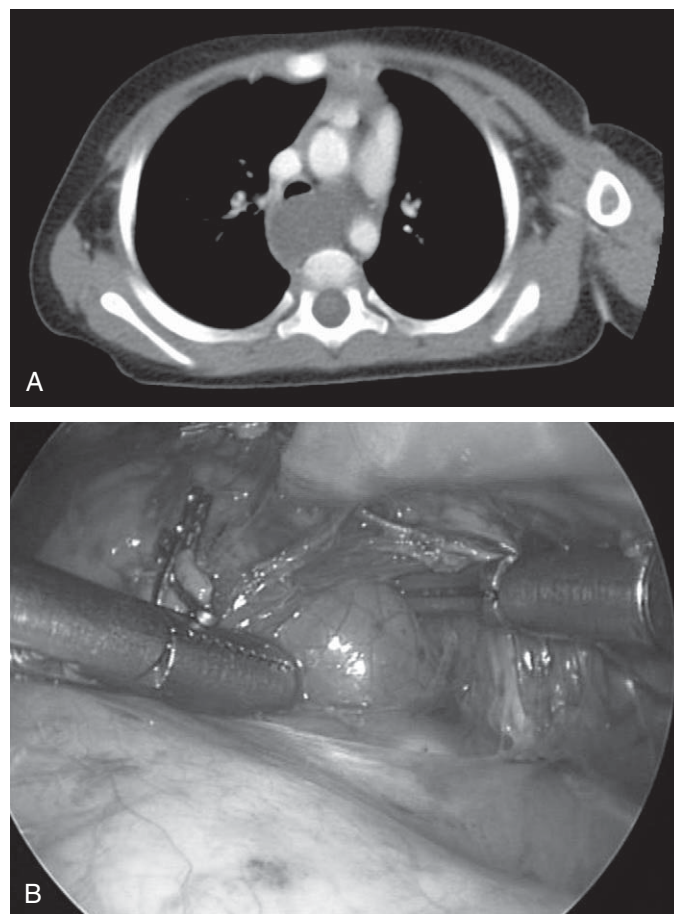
■ A, CT scan of a bronchogenic cyst. The cyst is compressing the posterior trachea. B, Thoracoscopic resection of a retrotracheal bronchogenic cyst.
